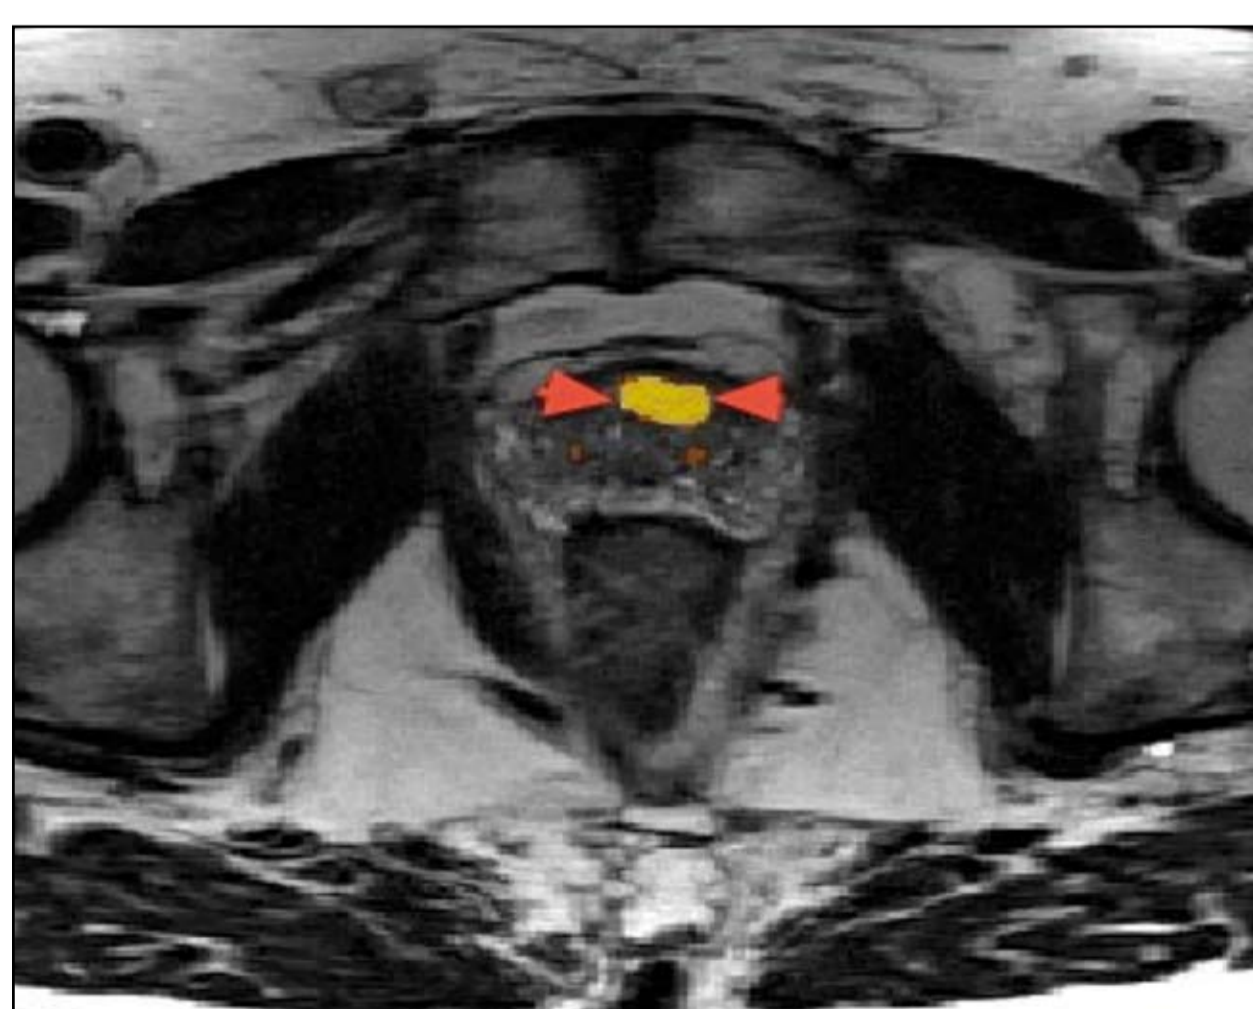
T2w MRI with superimposed b2000 in a 64-year old man who underwent two previous negative biopsy series both by TRUS and transperineal approach. The tumor appears yellow.
